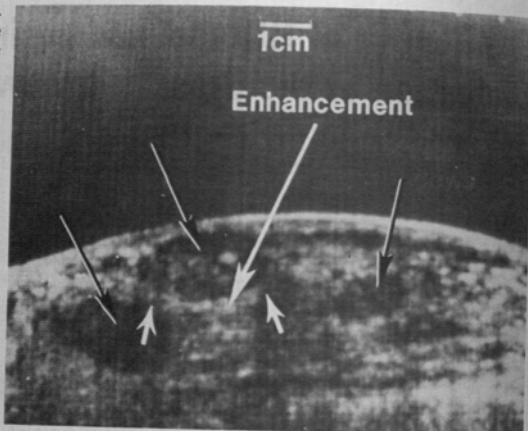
Ultrasound image obtained from a transverse scan of breast of a young, pregnant patient with multiple fibroadenomas.
